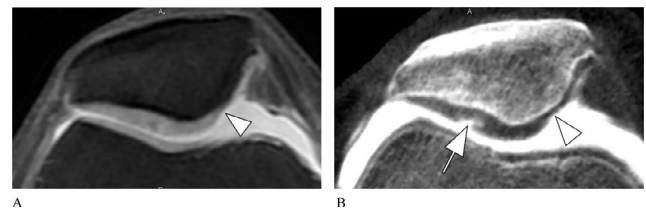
Axial intermediate-weighted fat suppressed MR shows superficial cartilage damage at the medial patella (arrowhead). The lateral patella is morphologically normal. B. Corresponding axial CT arthrography also shows medial patellar cartilage damage in comparable fashion but also depicts a focal superficial cartilage lesion at the lateral patella not seen on MRI (arrow).
